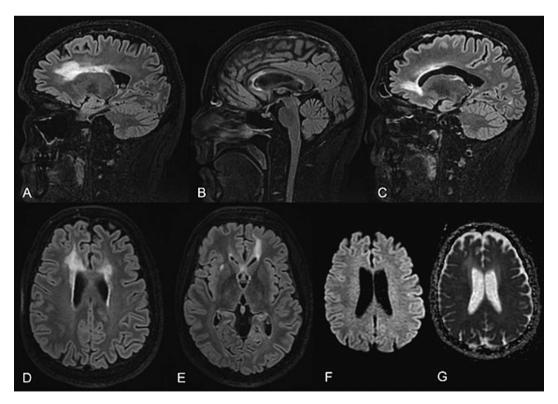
Brain MRI. A-C T2-weigted fluid-attenuated inversion recovery (T2-FLAIR) sagittal scans show extended white matter hiperintensities at bilateral frontal periventricular areas (right parasagittal plane – A; left parasagittal plane – C) and involvement of the rostum, genu and anterior part of the body of corpus callosum (midsagittal plane – B); D-E T2-FLAIR weighted axial scans show asymmetrical confluent high signal involving bilateral anterior periventricular areas, with subcortical extension, sparing the U-fibers (corona radiata level – D; basal ganglia level – E); F-G The diffusion-weighted image (DWI – F) and apparent diffusion coefficient (ADC – G) map show absence of restricted diffusion in the abnormal white matter.
